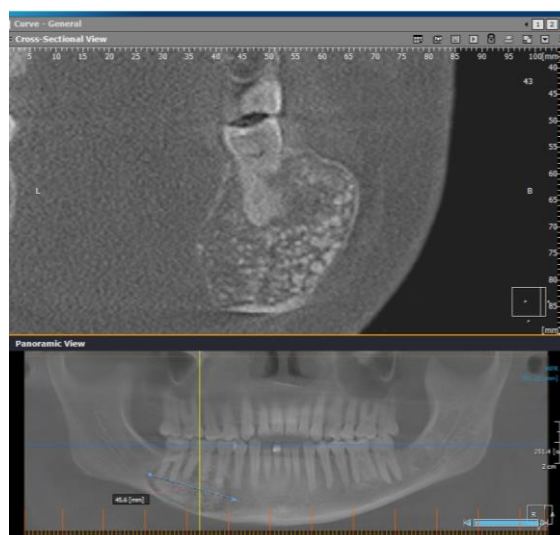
Initial CBCT (Transaxial slice through lesion).
